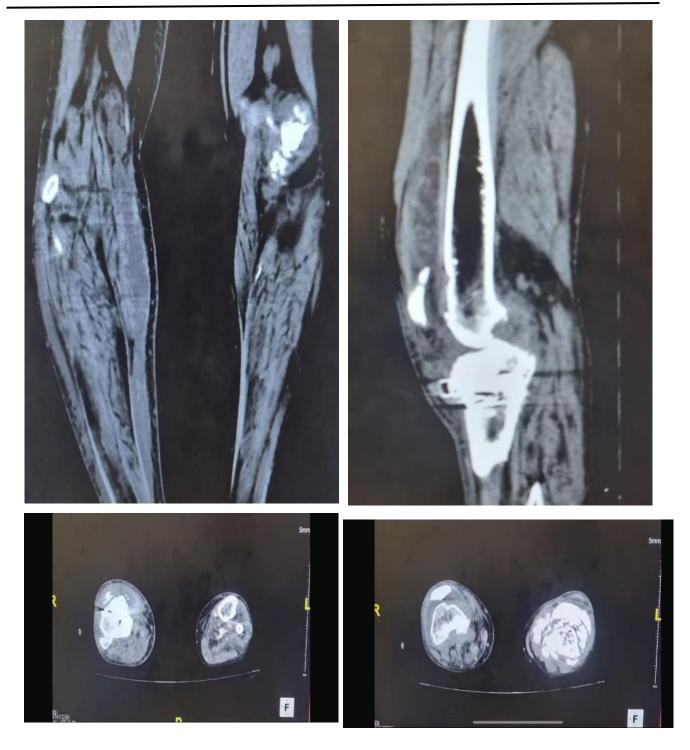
CT Scan of the knees (Frontal, sagittal, and axial)
